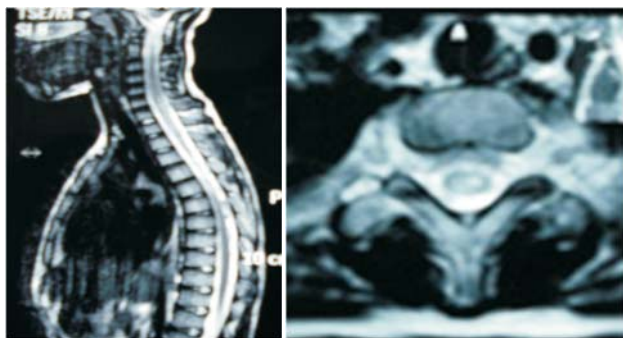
T2-weighted sagittal and axial MRI images of the cervico-dorsal spine showing a hyperintense intramedullary signal involving the cord from C6 to D8 level.
